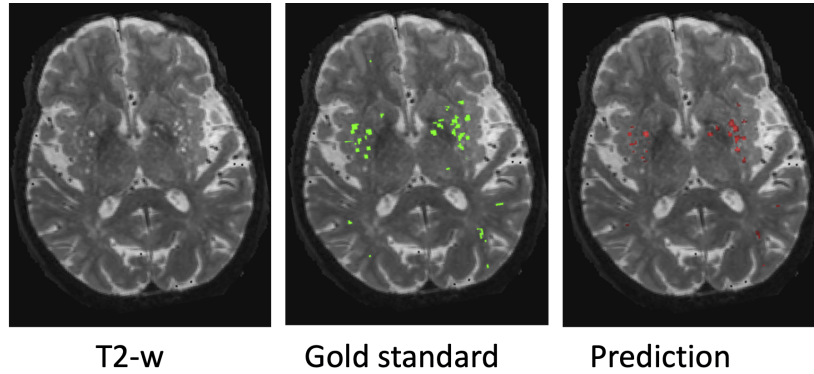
Segmentation visualization Overlaid on a Full 3D T2-weighted MRI Scan.
